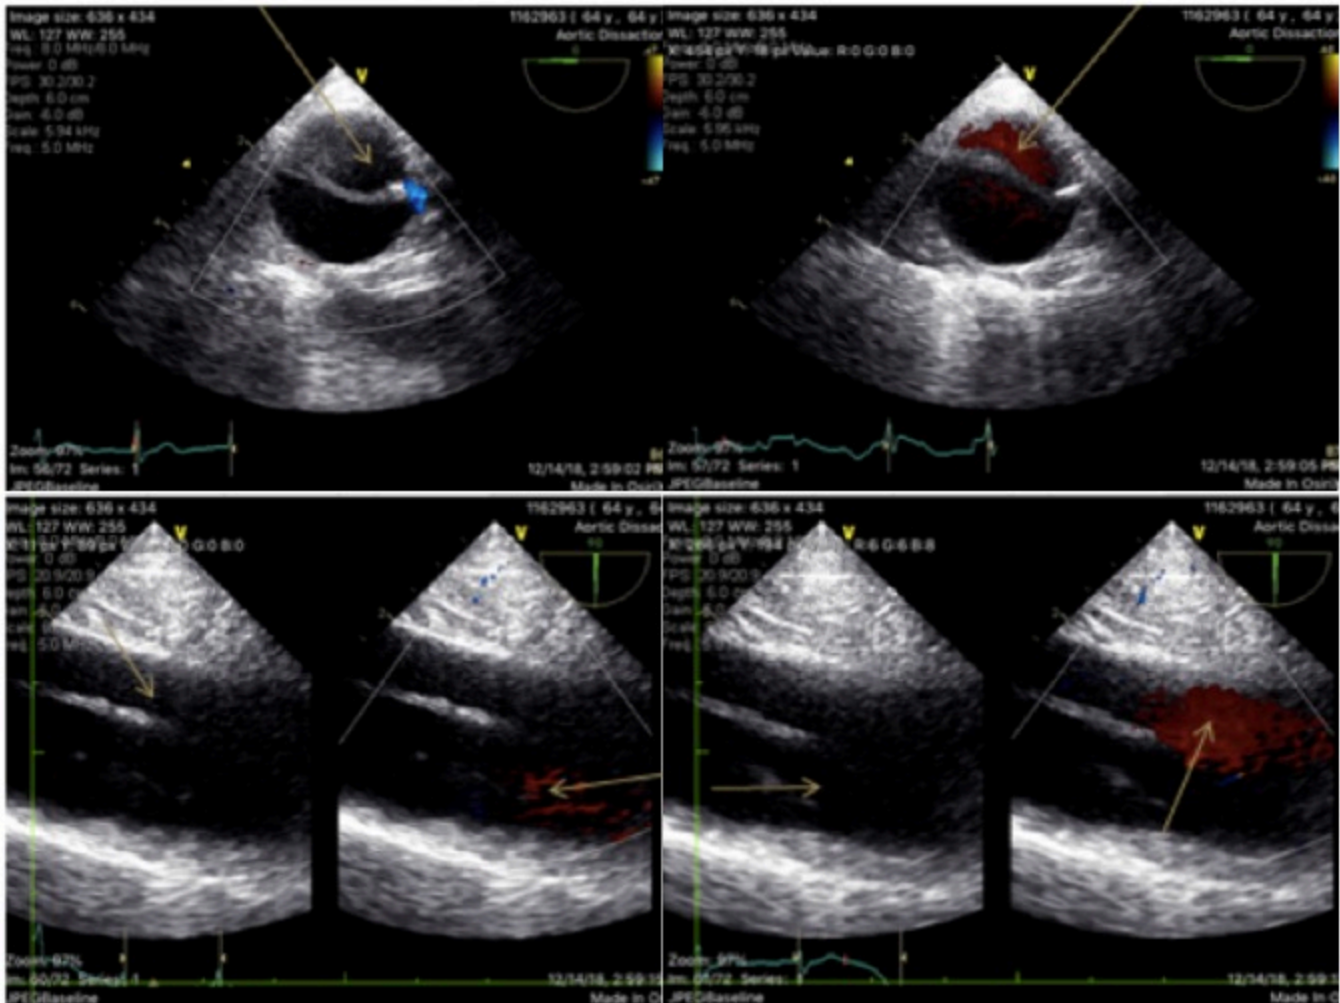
In these transverse echocardiographic views of the aorta, the ascending aorta appears dilated. A linear structure is visualized extending from the aortic root into the aortic arch and descending aorta. True and false lumens were visualized. These findings are suggestive of a type A aortic dissection. The arrows in the top left and right images denote the false lumen. The arrows in bottom left and right images highlight the exposure of a dissection flap with the false lumen exposed.
